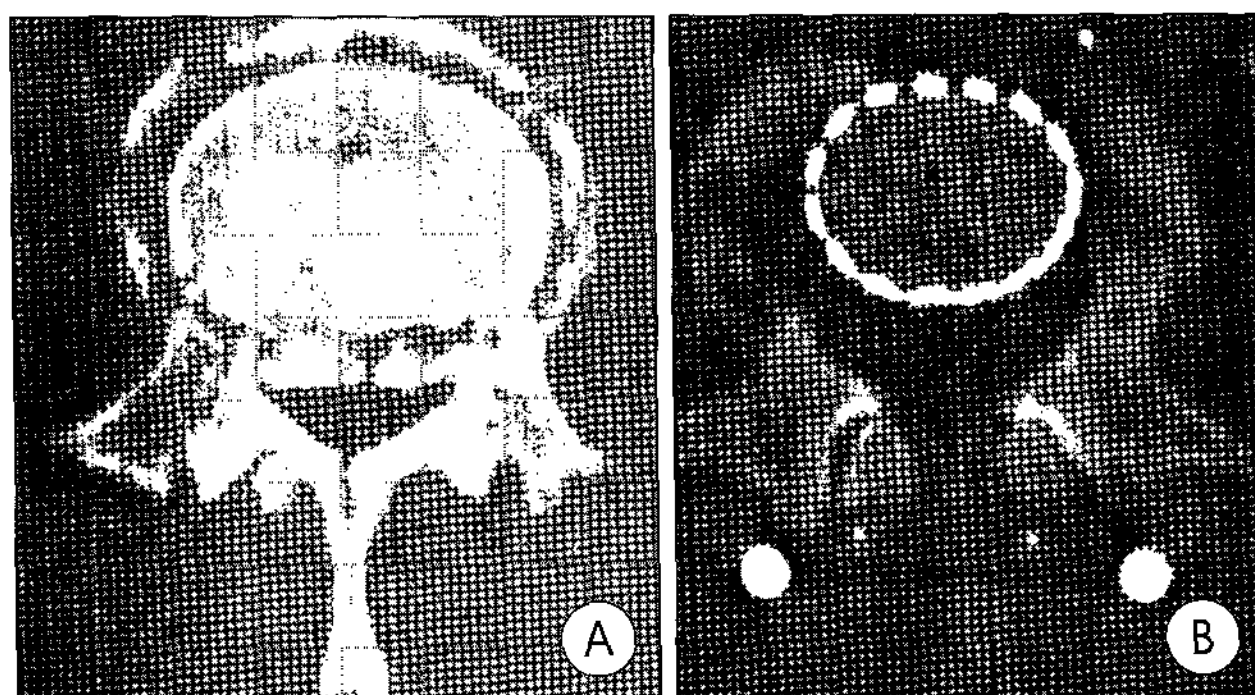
Preoperative axial computed tomography scan of case 3 (A) shows retropulsed bony fragments encroaching spinal canal. Postoperative axial computed tomography scan (B) demonstrating fully decompressed spinal canal and well positioned cage.
